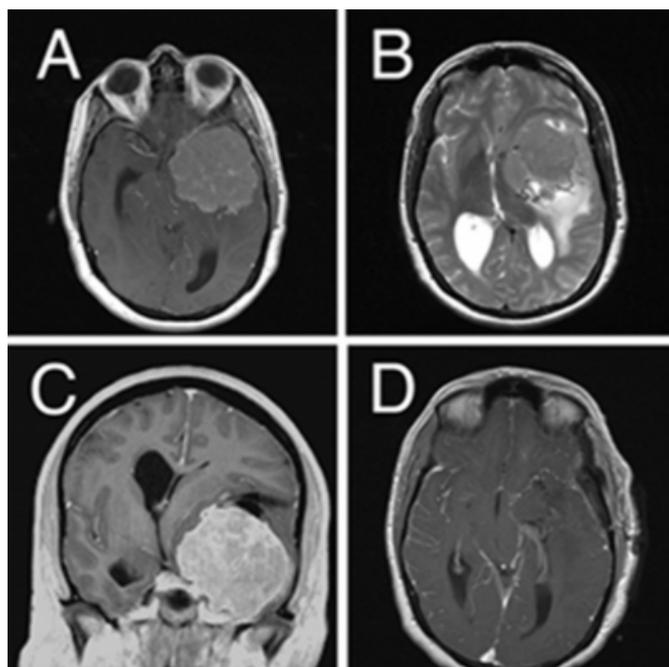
Preoperative MRI shows a large lateral sphenoid wing meningioma causing significant mass effect and edema on the left temporal lobe, insula and frontal operculum (Figure A, B & C). She underwent left pterional craniotomy and gross-total resection of the mass without neurological complication (D).
